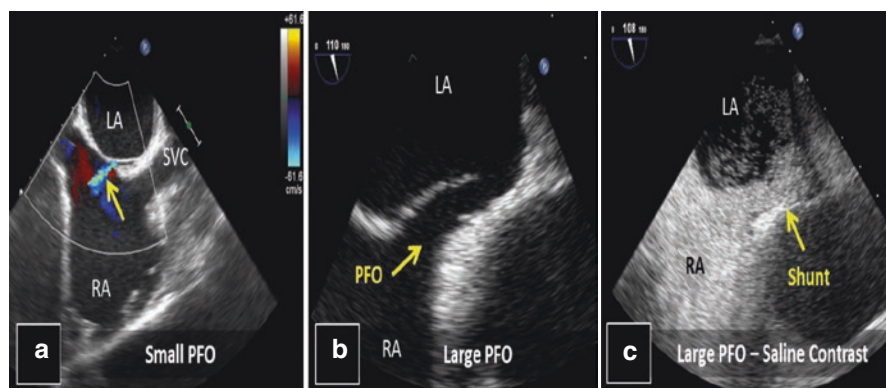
PFO. (a) Small PFO visualized with color Doppler. (b) Large PFO can be visualized without assistance of color Doppler or agitated saline. (c) Communication between right and left atrium in large PFO with significant proportion of bubbles crossing the interatrial septum during bubble study. *PFO* Patent foramen ovale, *LA* Left atrium, *RA* Right atrium, *SVC* Superior vena cava
